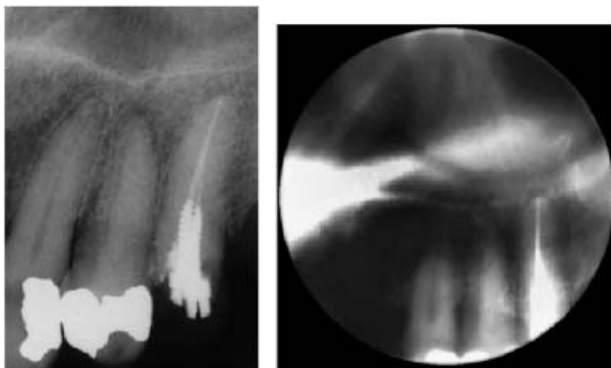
Cropped intraoral radiograph (left) of a premolar tooth, and a spiral tomogram (right) that better visualizes the lesion at its apex. Courtesy of Tapio Tammissalo.
